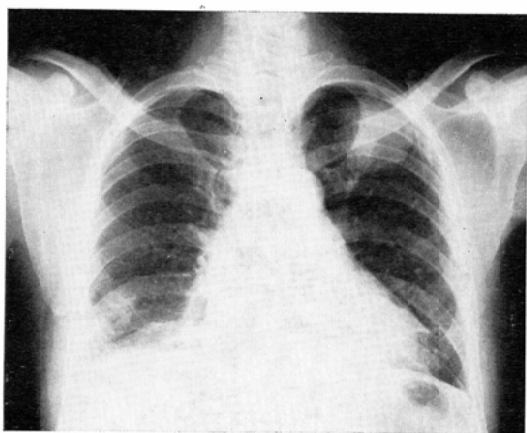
Chest X-ray film in February 1970, 10 days after the admission showing the large nodular densities with 5cm in diameter in the apex of the left lung and slight pleural effusion.
